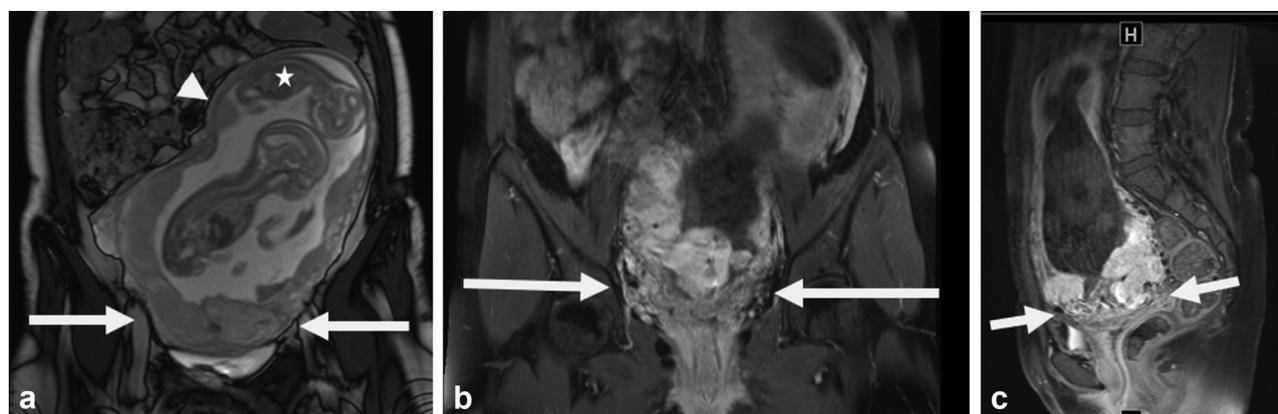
MR image of a 39-year-old woman during the 20th week of pregnancy. (a) Coronal T2w image showing the placenta extending from cranial (arrowhead) to isthmicocervical (arrows) and 2 fetuses with different gestational ages, 1 with appropriate gestational age, and 1 with intrauterine growth retardation (star). Contrast-enhanced T1w images with fat-suppression in (b) coronal and (c) sagittal orientation visualize the hyperperfused region at the isthmicocervical junction (arrows).
